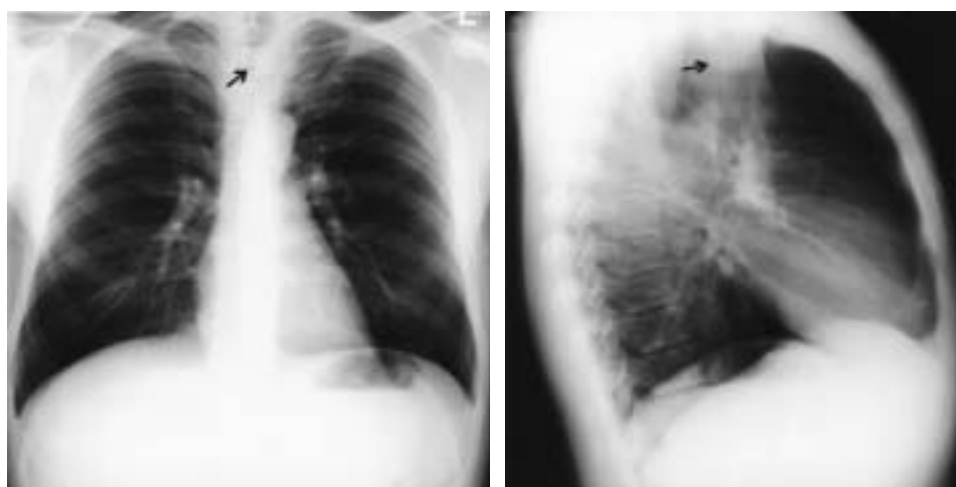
Plain posteroanterior (left) and lateral (right) chest radiographs showing round mass (arrow) in the upper trachea.
